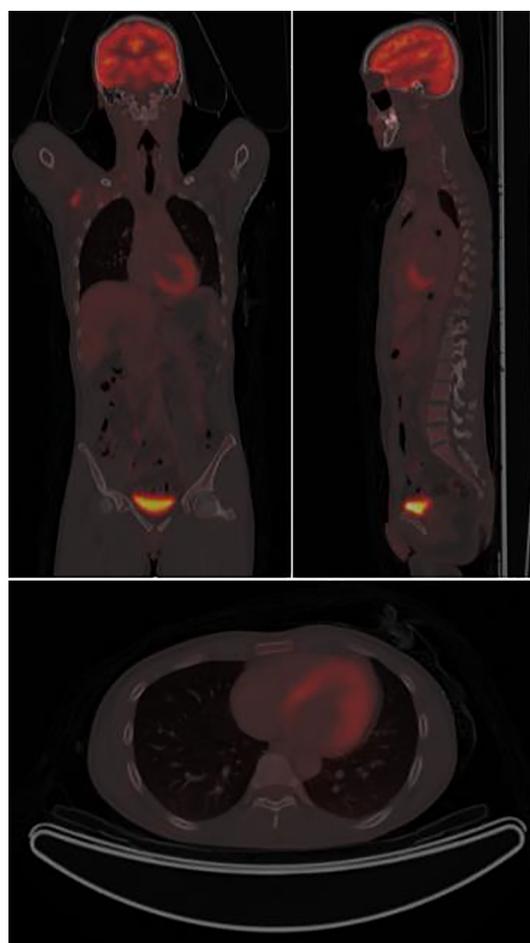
The PET/CT image of the patient.
